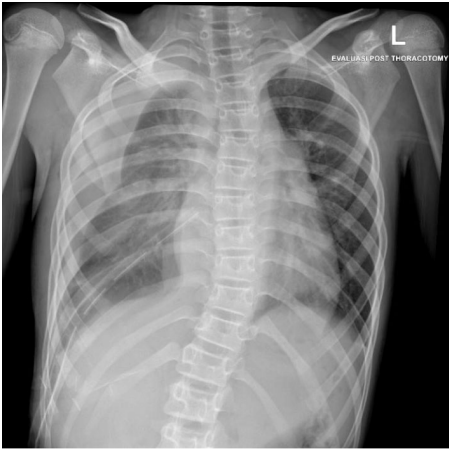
Post-operative chest x-ray showed complete excision of the mass and expansion of the right lung.
